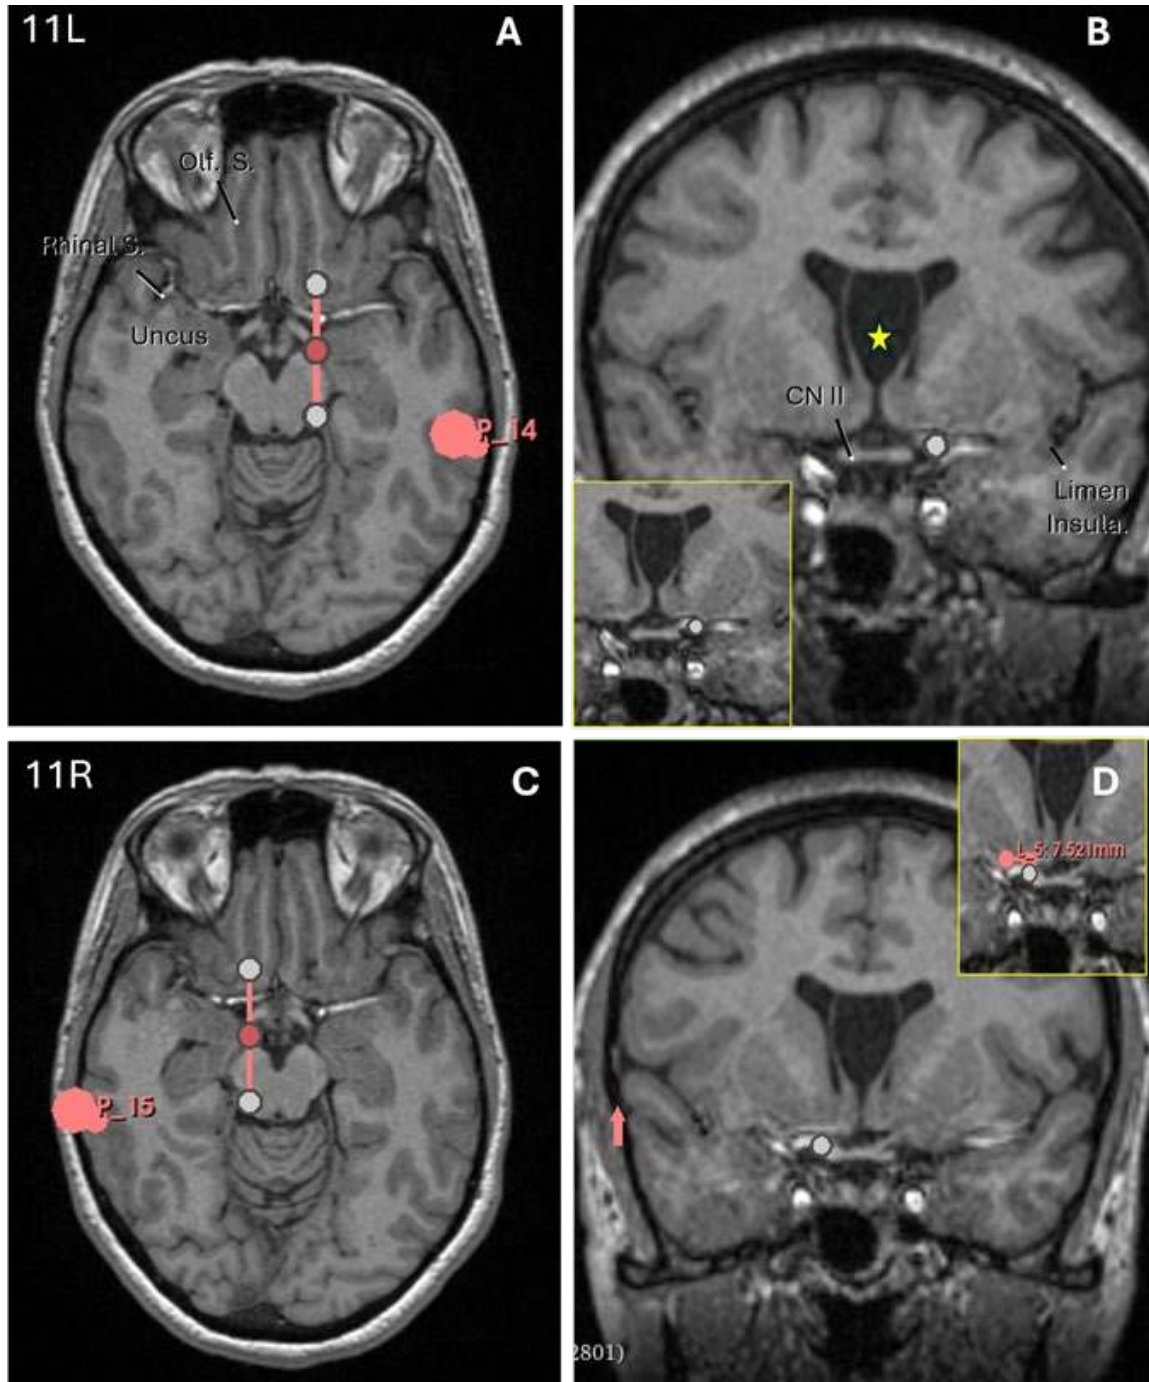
Left (A and B) and right (C and D) MRI scans of patient 11. The sagittal plane was plotted using the posterior part of the olfactory sulcus as seeing on the axial scans (A and C). Although the coronal image on the right (B) revealed that this plane was coincident with the carotid bifurcation, on the left this plane led to a point 7.42mm medial to that. The alignment of this sagittal plane with the medial apex of the uncus and the lateral mesencephalic sulcus is also seen here. CN: Cranial Nerve; S.: Sulcus; Olf.: Olfactory. Yellow Star: Cavum septum pellucidum.
